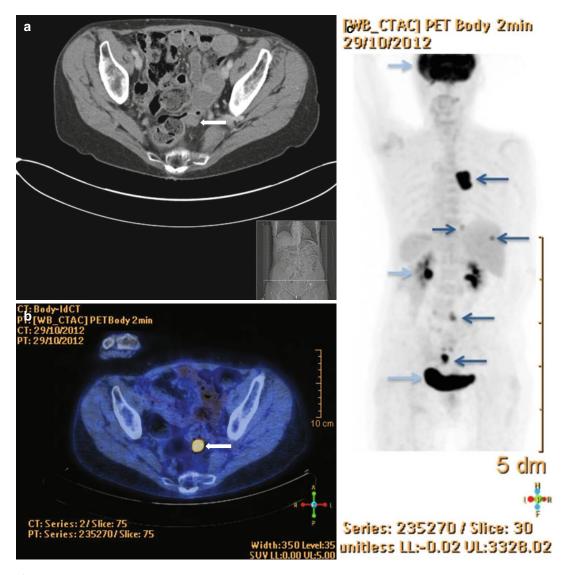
Axial contrast enhanced CT image through the pelvis (a) corresponding fused PET/CT image (b) and whole-body coronal MIP 18F-FDG-PET image (c) in a woman with recurrent ovarian cancer. There is a pelvic peritoneal deposit posterior to a small bowel loop (a, *arrow*) which has similar appearances to bowel and could easily be overlooked on CT, however there is intense tracer uptake on the fused PET/CT (b, *arrow*) consistent
